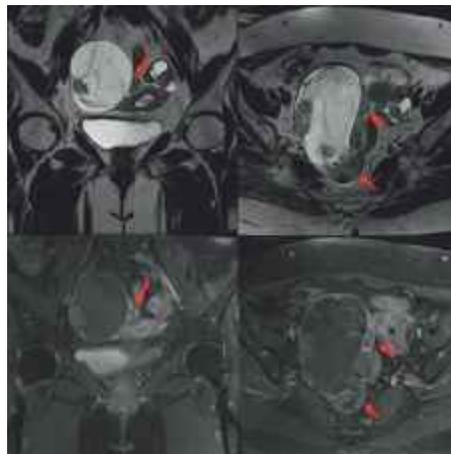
These MRI images of the pelvis - T2WI coronal (upper left image), T2WI axial (upper right), T1WI post contrast coronal (lower left image) and T1WI post contrast axial (lower right image) reveal an ovoid mixed solid-cystic lesion in the right adnexa. The cystic component (hyperintense on T2 weighted images) showed evidence of layering within. The solid component was seen to be continuous with the ipsilateral fallopian tube (red arrows), which showed diffuse mural thickening in its entire extent, up to the right uterine horn. The solid component, along with the thickened fallopian tube showed heterogeneous post-contrast enhancement. The right ovary was not seen separately from this lesion. Fat planes with surrounding hollow viscera appeared maintained. A smaller, similar lesion was noted in the left adnexa
